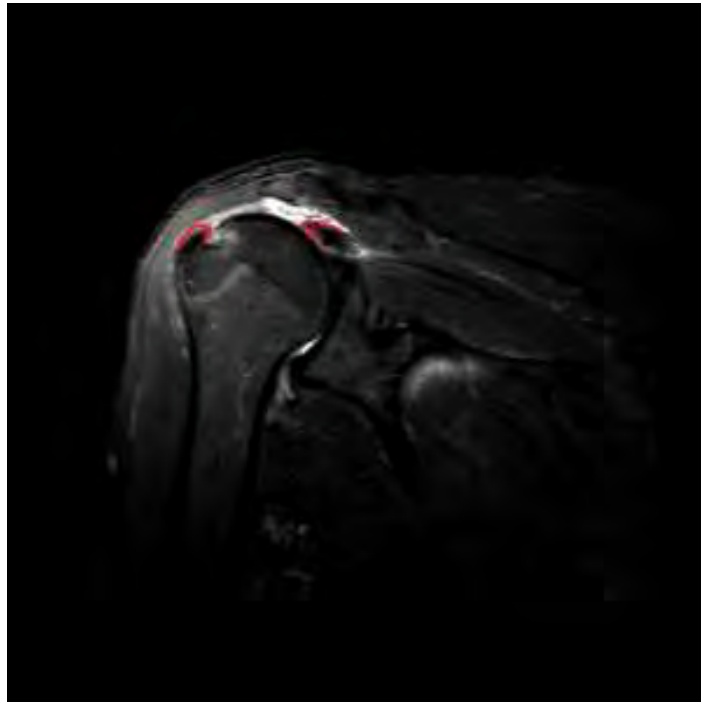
An MRI of a torn supraspinatus. The edge of the tendons are shown in red. (Case courtesy of Dr Ahmed Abdrabou, Radiopaedia.org, rID: 36724)
